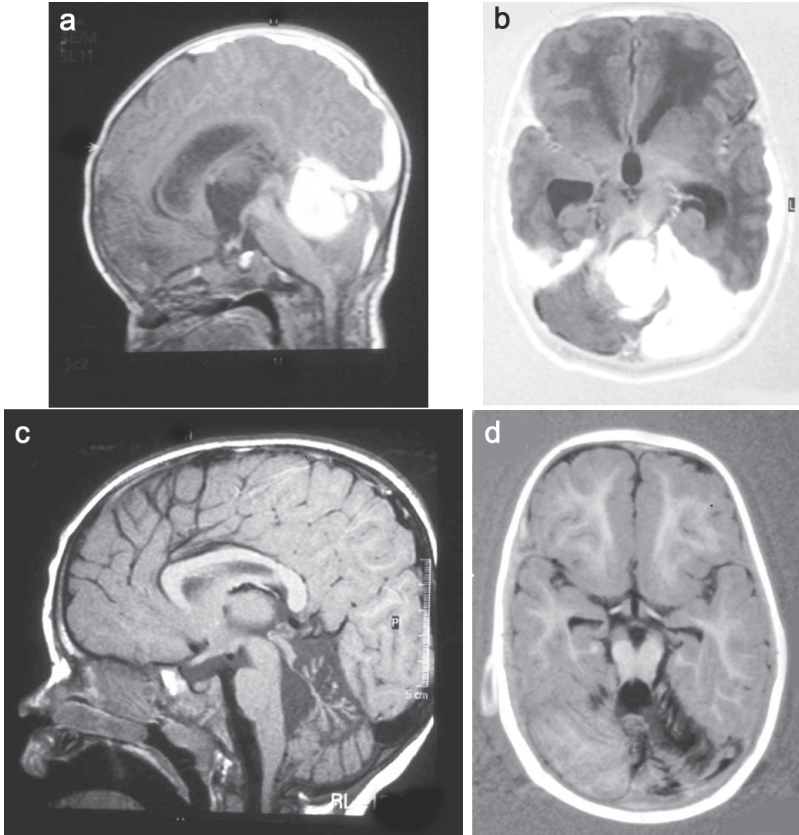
MRI, T1-weighted spinecho, midsagittal view (a), and IR, axial view (b), both obtained on day 10; T1-weighted SE, midsagittal view (c) and IR, axial view, obtained at 18 months of age (c,d). A large infratentorial haemorrhage involving the left cerebellar hemisphere and the fourth ventricle is seen. There is also a supratentorial SDH (a,b). Follow-up MRI shows severe atrophy of the vermis and the left cerebellar hemisphere (c,d). The child developed severe ataxia and also has growth hormone deficiency.
